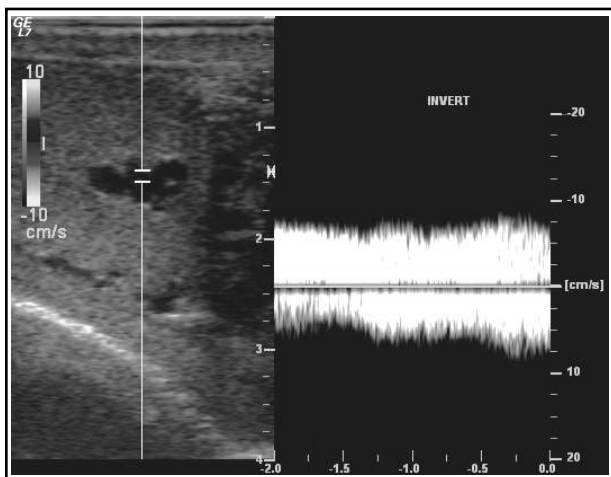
Duplex Doppler US showed that venous flow increased in these intratesticular tubular structures during Valsalva's maneuver.
